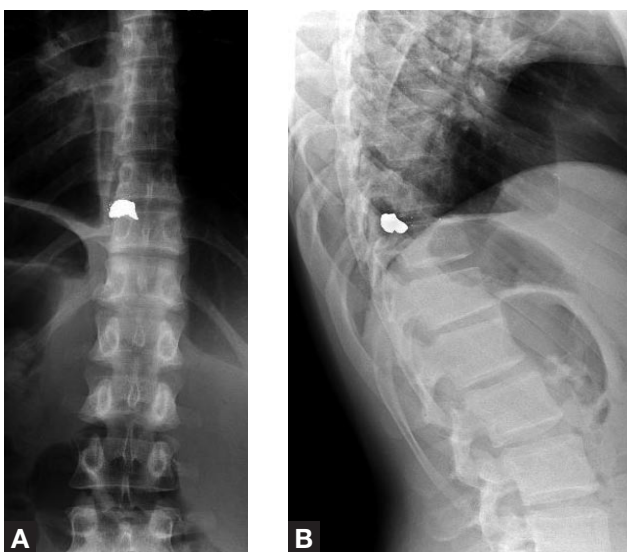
Anteroposterior (A) and lateral (B) x-rays show missile fragment lodged in T10–T11 foramen.
